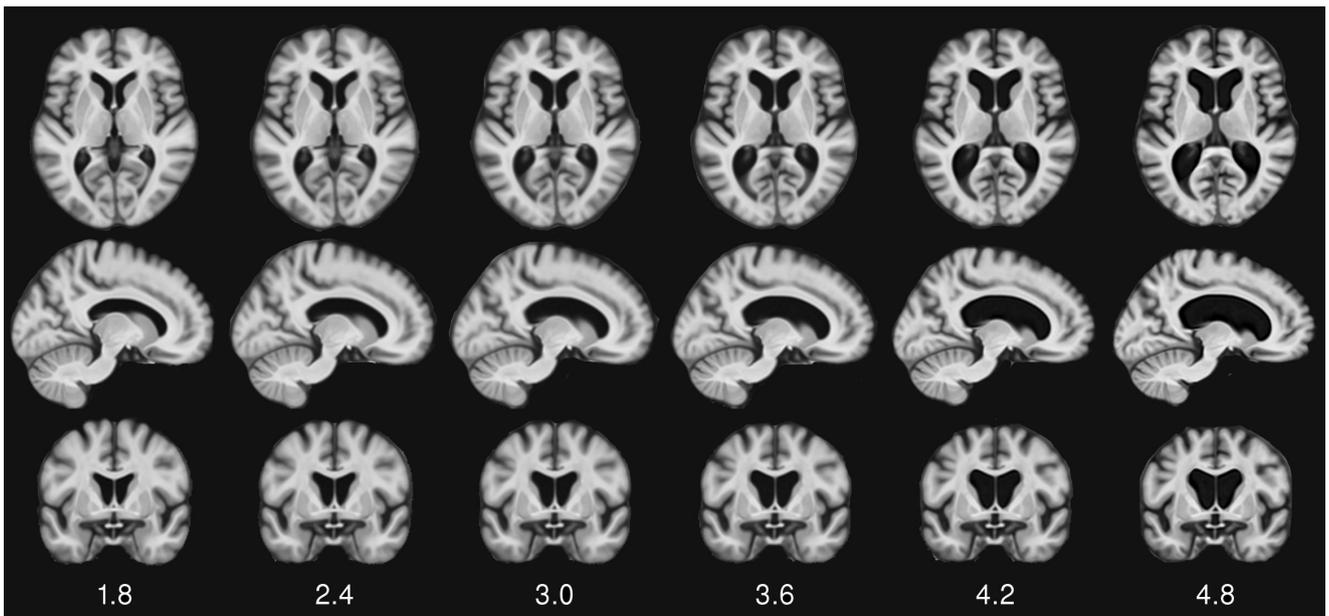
Atrophy specific MRI brain template sampled at various relative lateral ventricles volume sizes, in percent of the Intra Cranial Capacity.
